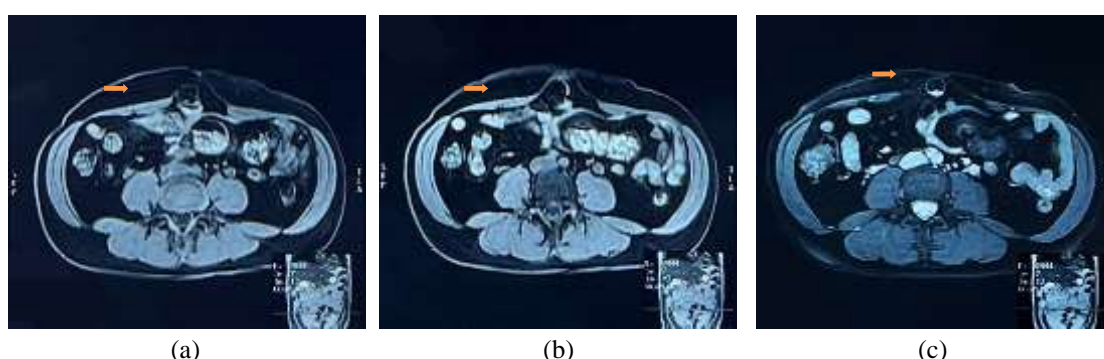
Preoperative computed tomography (CT) imaging of the abdomen, highlighting three specific regions: (a) superior to the umbilicus, (b) at the level of the umbilicus, and (c) 2 cm inferior to the umbilicus.
